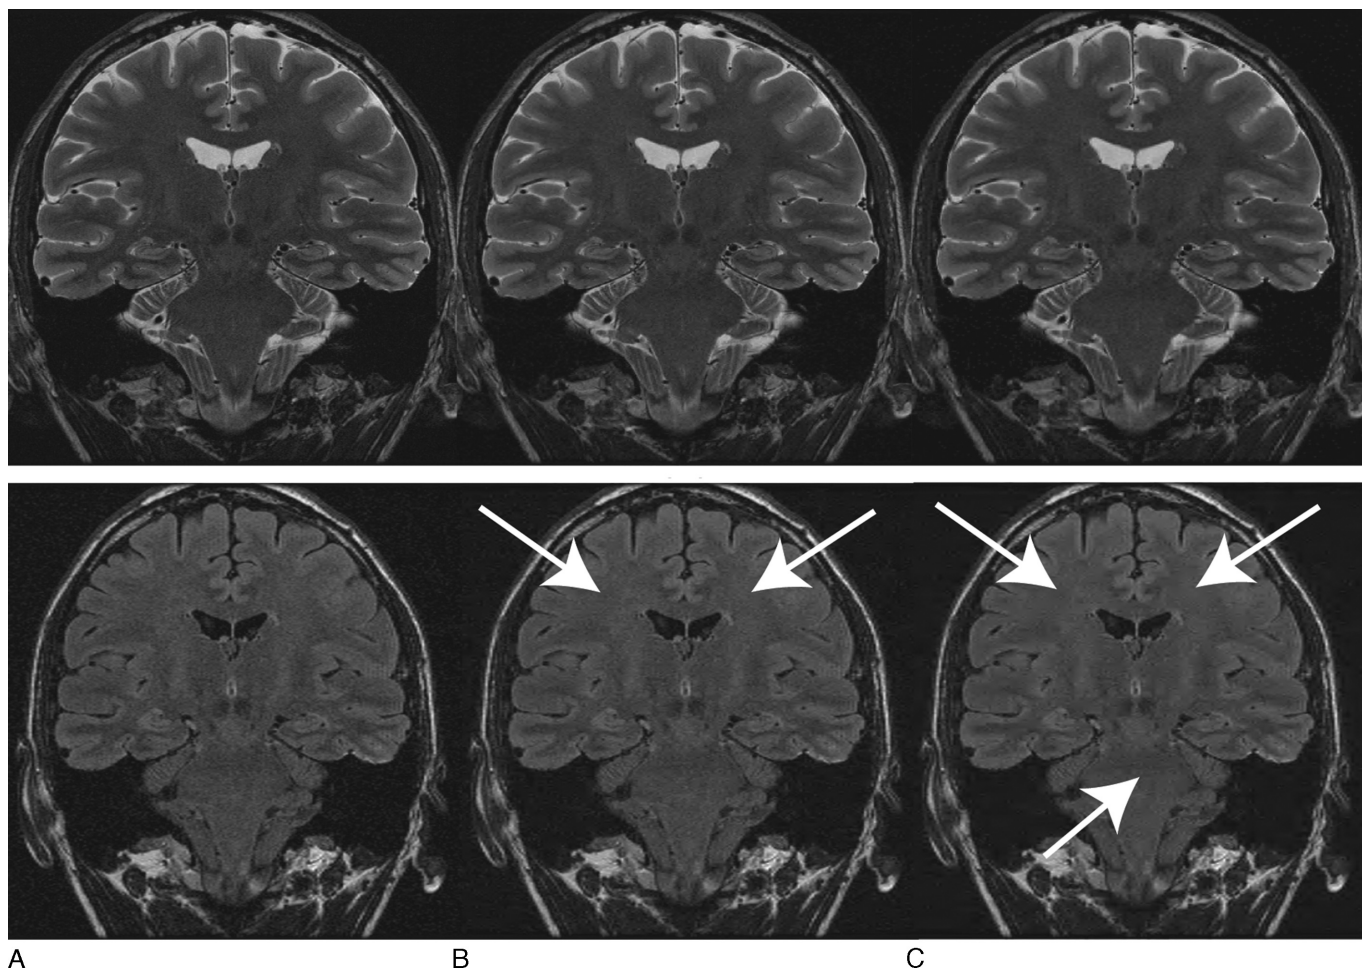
Images formed using a fractional amount of the available DB-4 wavelet coefficients. For each image, a fraction of the highest magnitude DB-4 wavelet coefficients was used to construct the image, with the other coefficients being set to 0. Top row: T2-SE; bottom row: T2-FLAIR. A, All DB-4 coefficients used; B, one-third of wavelet coefficients used; C, one-fifth of wavelet coefficients used. At one-third of the coefficients, the T2-FLAIR image suffers from noticeable blurring, which is amplified when only one-fifth of the coefficients are used (see white arrows). The effects on the T2-SE images are not as apparent. This indicates that images from the T2-SE sequence are relatively more compressible than the images from the T2-FLAIR sequence, which may explain why the qualitative scores were better for the T2-SE sequence for a fixed acceleration factor.
